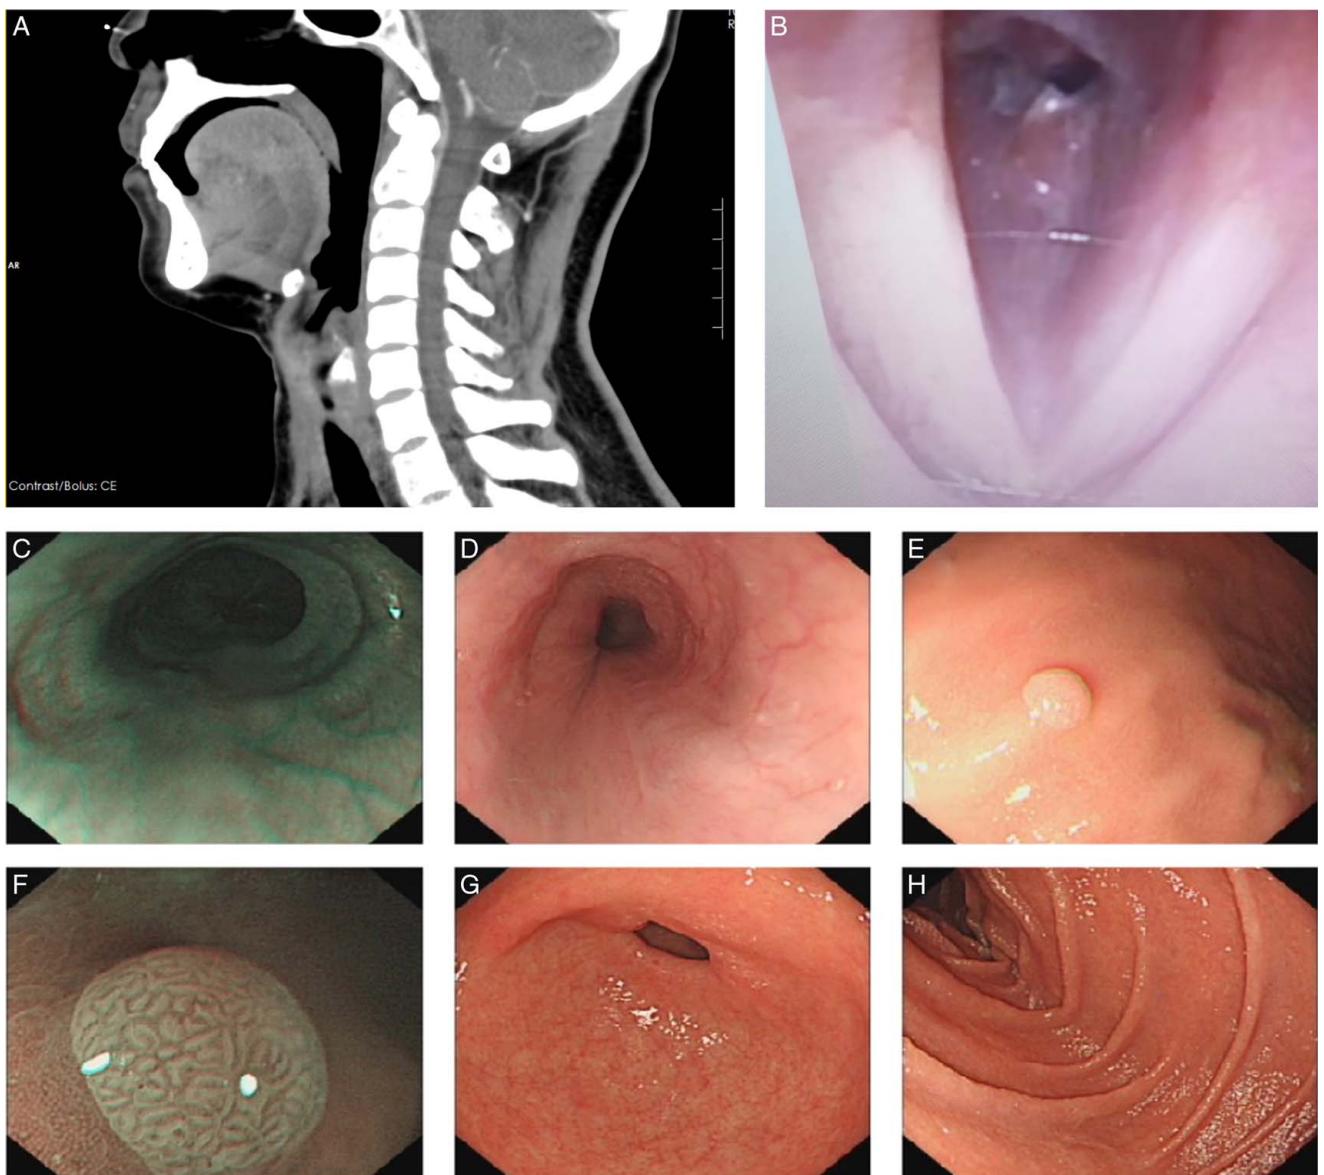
Preoperative neck and chest computed tomography scans indicated trachea stenosis in the cricoid cartilage plane (A). Subglottic mass can be seen under the laryngoscope (B). To exclude tumours from the oesophagus, no malignant tumour was found in the oesophagus and gastroscopically (C–H).
